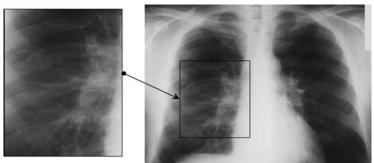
The chest X-ray of patient with bronchitis
